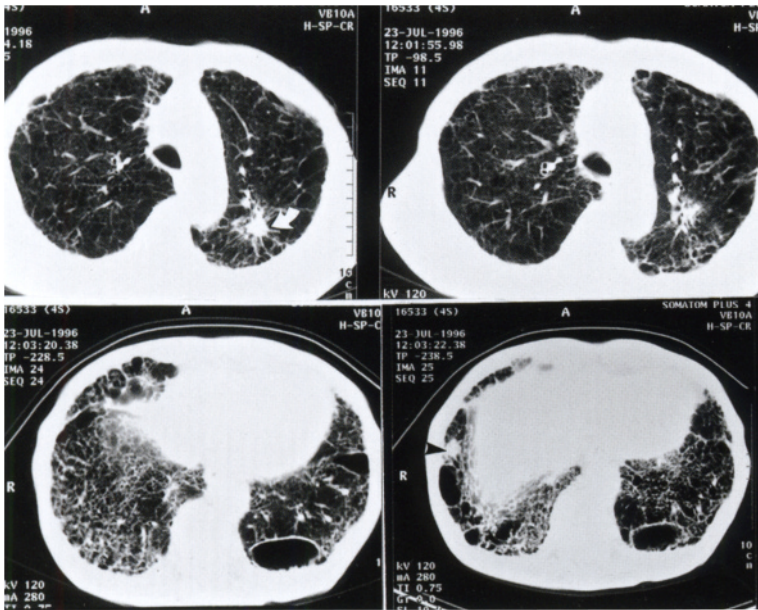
CT images demonstrate dense distribution of reticular and linear opacities throughout the lungs accompanied with pulmonary emphysema and bullae. There are two nodules suggesting lung cancers, one in the left upper lung (*white arrow*), and the other in the right lower lung (*black arrowheads*)
